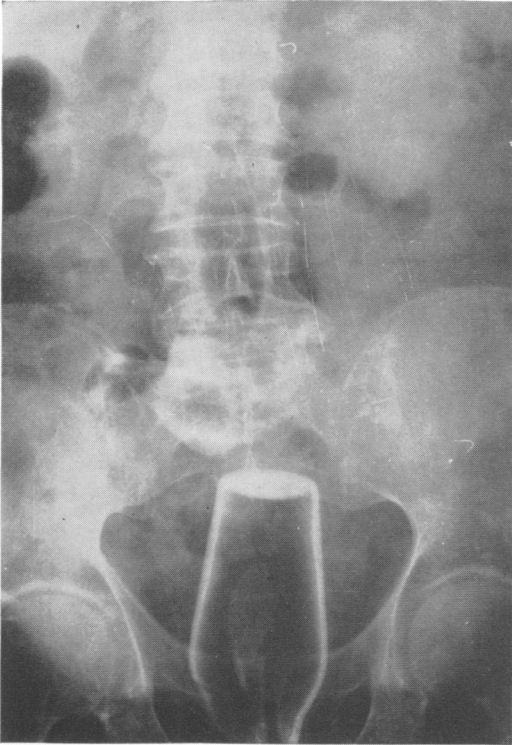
Roentgenogram of abdomen showing foreign body (bottle) in rectum. The base of the bottle is directed cephalad. A fragment of glass lies within the bottle.
